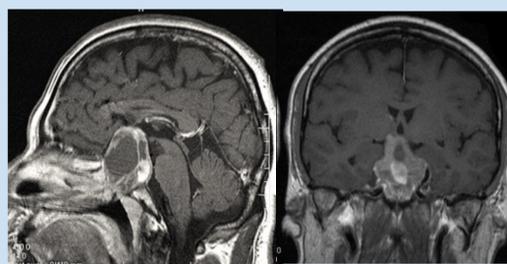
MRI 2007 afunctional adenoma
